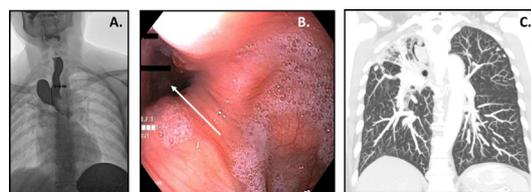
(A) Barium oesophagogram. (B) Endoscopic view of the diverticulum. (C) Follow-up CT of the chest.
